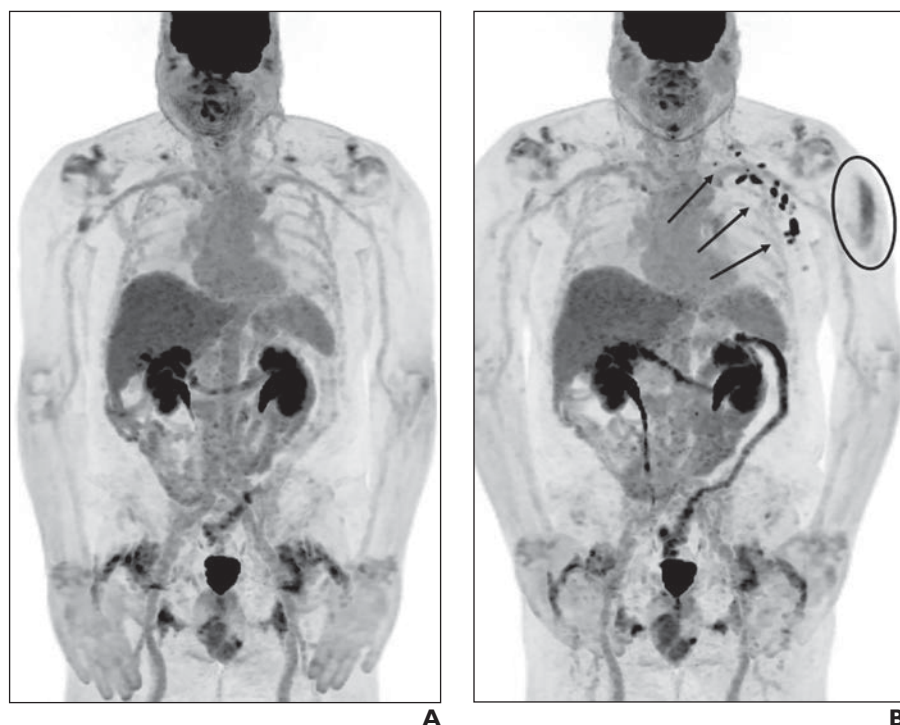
72-year-old man with metastatic colon cancer who was receiving pembrolizumab immunotherapy. Patient received second dose of SARS-CoV-2 mRNA-1273 vaccine (Moderna) in left deltoid 4 days before undergoing FDG PET/CT. A, FDG PET/CT image obtained before vaccination shows no hypermetabolic metastatic disease. B, FDG PET/CT image obtained after vaccination shows multifocal FDG uptake within left axillary and supraclavicular lymph nodes (arrows) ($SUV_{max} = 9.6$) and elongated FDG uptake within lateral head of left deltoid muscle (oval) ($SUV_{max} = 2.9$) with pattern that follows muscular striations.
